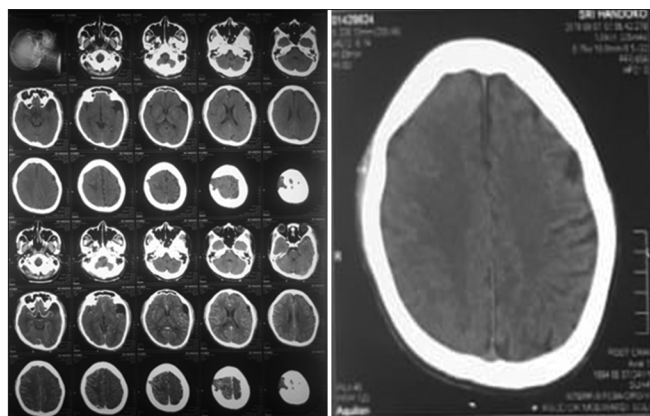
Computed tomography scans with contrast, after seizure and left hemiparesis, day 16th after the surgery
